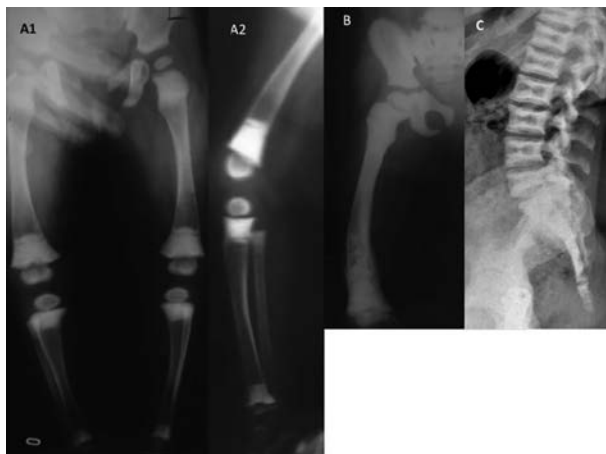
A. Radiographs in early childhood show metaphyseal and epiphyseal sclerosis. B. At age 6 years there is diffuse osteosclerosis and flaring in the metaphyses and metadiaphyses, cortical thinning and bowing. C. At age 17 years there is platyspondyly with sandwich vertebrae.
